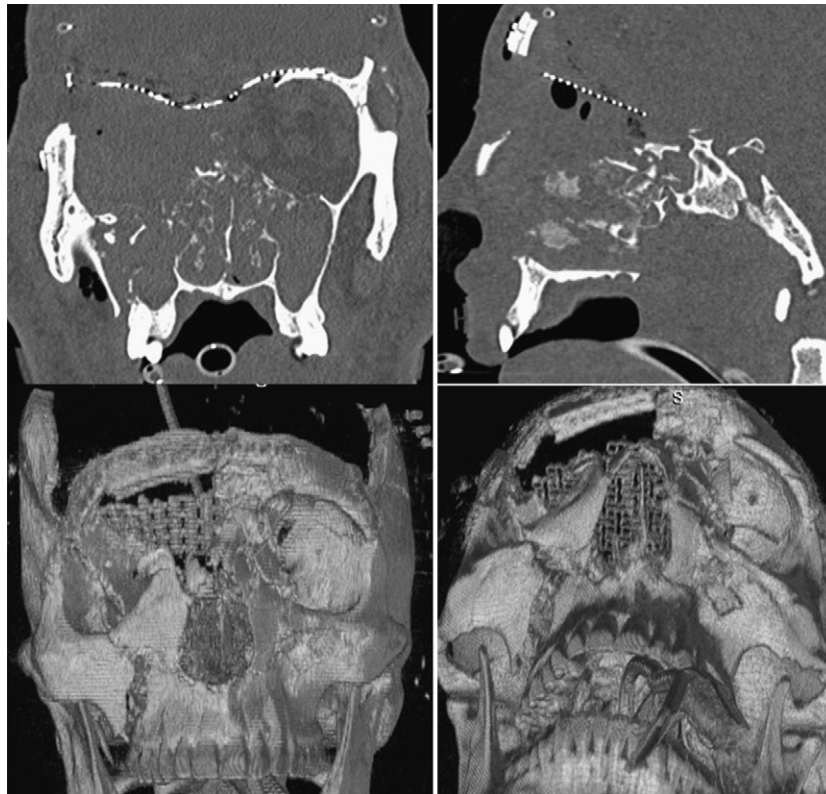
Postoperative CT images and 3-dimensional reconstructions of the patient in Fig. 11. The anterior fossa floor was reconstructed with titanium mesh and the right orbital bandeau was preliminarily reconstructed using autologous cranial bone graft. The patient's Le Fort III fracture was repaired in delayed fashion. Previously it was the authors' preference to use titanium mesh, as was done in this case. Delayed complications with mesh have occurred and reoperation has been challenging. The authors now use split-thickness calvarial graft instead of mesh, when and where possible, when reconstructing the cranial floor and orbital bandeau.
